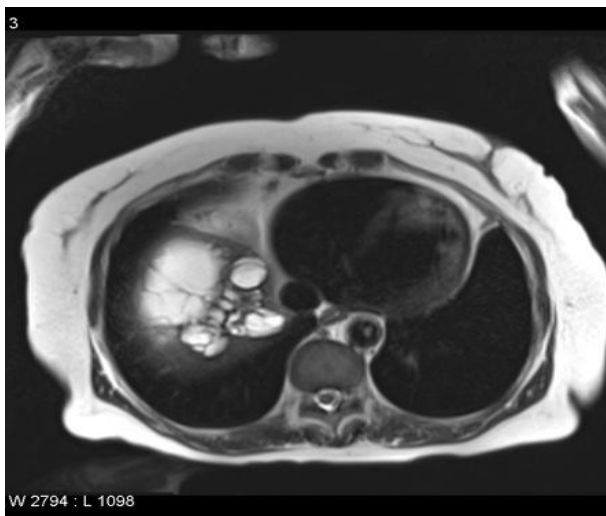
MRI showing the cyst
